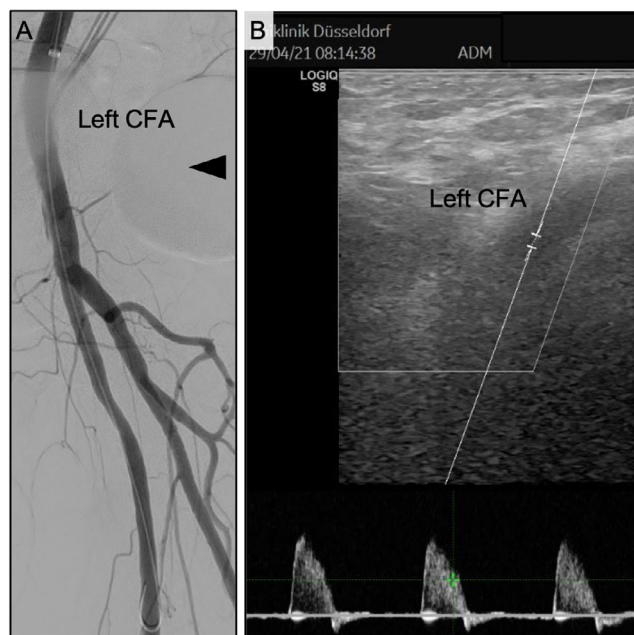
Occlusion of the left common femoral artery. (A) Left common femoral artery ultrasound examination revealing a severe impairment of blood flow. (B) Subtotal occlusion of the left common femoral artery due to an intravascular collagen plaque (black arrow). (C) Angioplasty of the closure site with an uncoated balloon. (D, E) Left common femoral artery angiogram showing an occluded bifurcation (black arrow) with an obstructed superficial and profunda femoral artery, most probably by an embolized *Angio-Seal*. A small dissection (white arrow, D) of the common femoral artery is visible, possibly due to angioplasty
